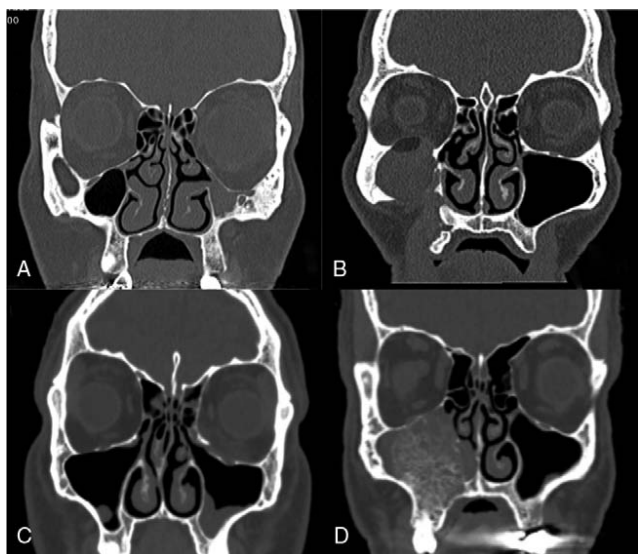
Preoperative CT scans showing: (a) a fibrous dysplasia involving the right maxillary sinus; (b) a case of KCOT in right maxillary sinus eroding the orbital floor; (c) a left orbital floor fracture; (d) a silent sinus syndrome. KCOT, keratocystic odontogenic tumor.
